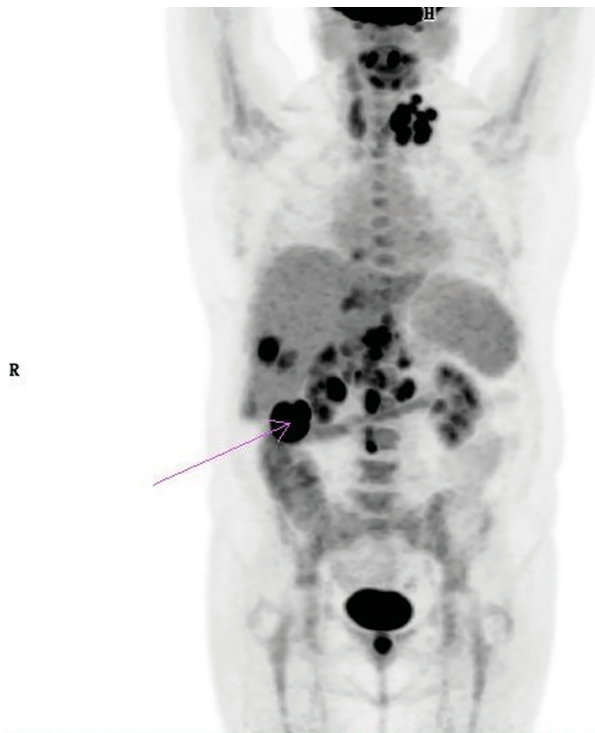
[^{18}F]FDG PET/CT coronal whole-body maximum intensity projection image. Synchronous colorectal cancer detected in [^{18}F]FDG PET/CT (hepatic flexure tumor) (arrow), metastases in the liver, supra- and infra-diaphragmatic lymph nodes. The [^{18}F]FDG PET/CT was performed due to suspicion of a liver metastatic lesion in the CT
